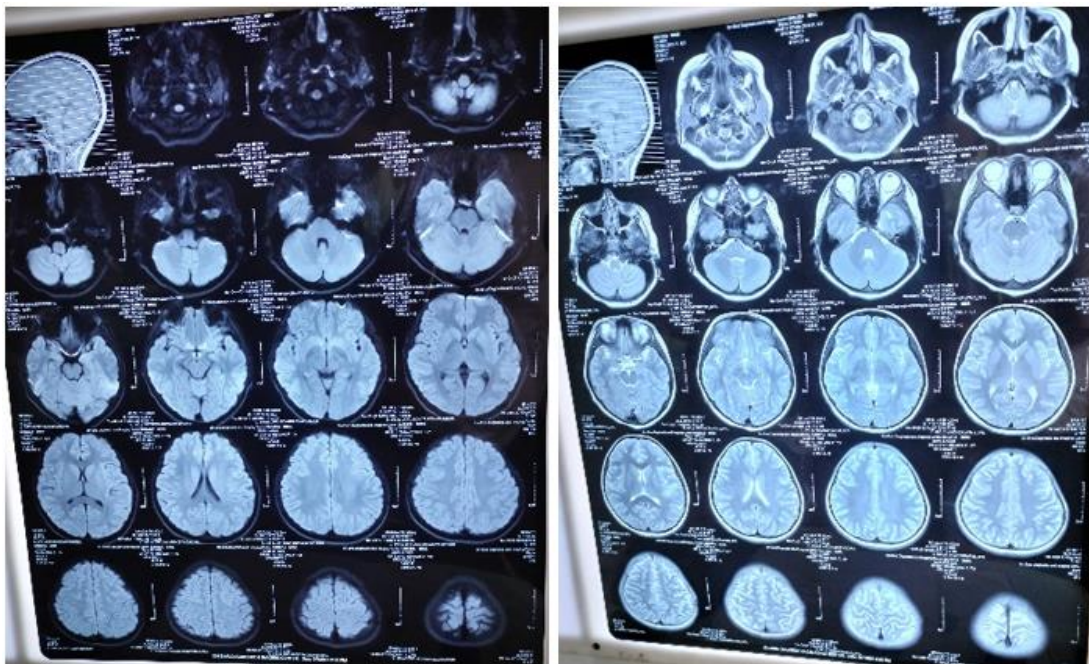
MRI findings of the patient
